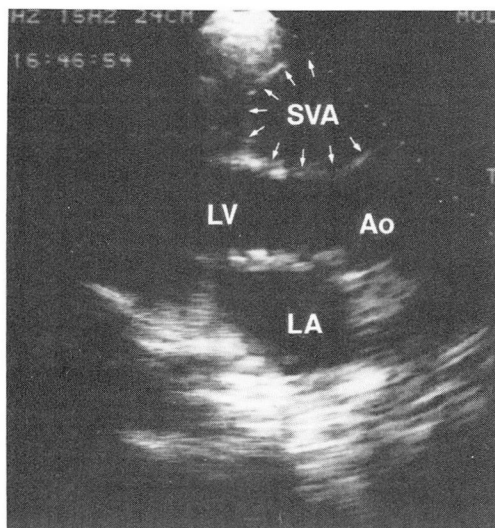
Two-dimensional echocardiogram, long axis parasternal view. Arrows point to a large round mass in the right ventricular outflow tract above the aorta. (SVA = sinus of Valsalva aneurysm; LV = left ventricle; Ao = aorta; LA = left atrium.)
